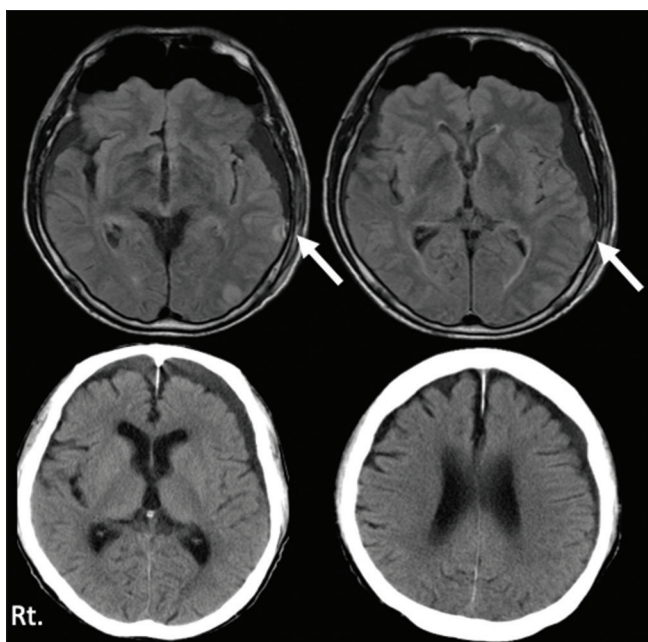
Postoperative images. Upper: Brain magnetic resonance imaging (FLAIR) showed hemostatic scar by monopolar coagulator (white arrow). Lower: Head computed tomography: Hematoma has been evacuated.
